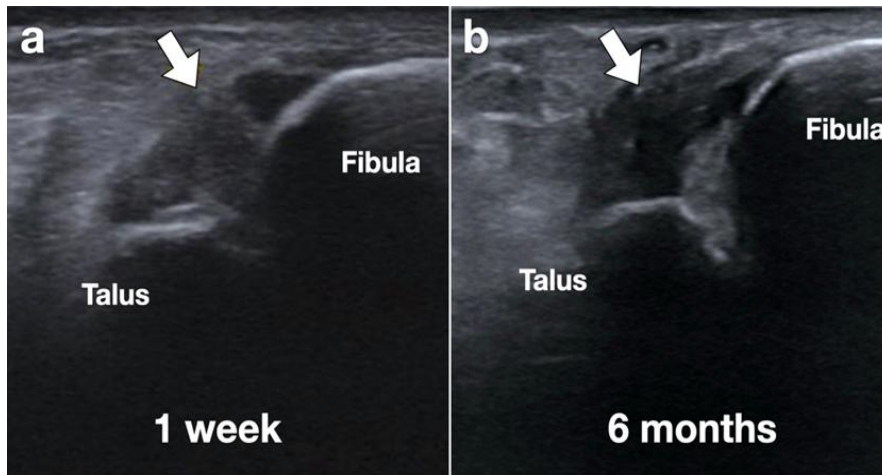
(a) Ultrasound of right ATFL (arrow) at 1-week post-injury. (b) An ultrasound at 6 months post-injection showed right ATFL thickening and healing with fibrosis, which corresponded to the findings in the MRI.
